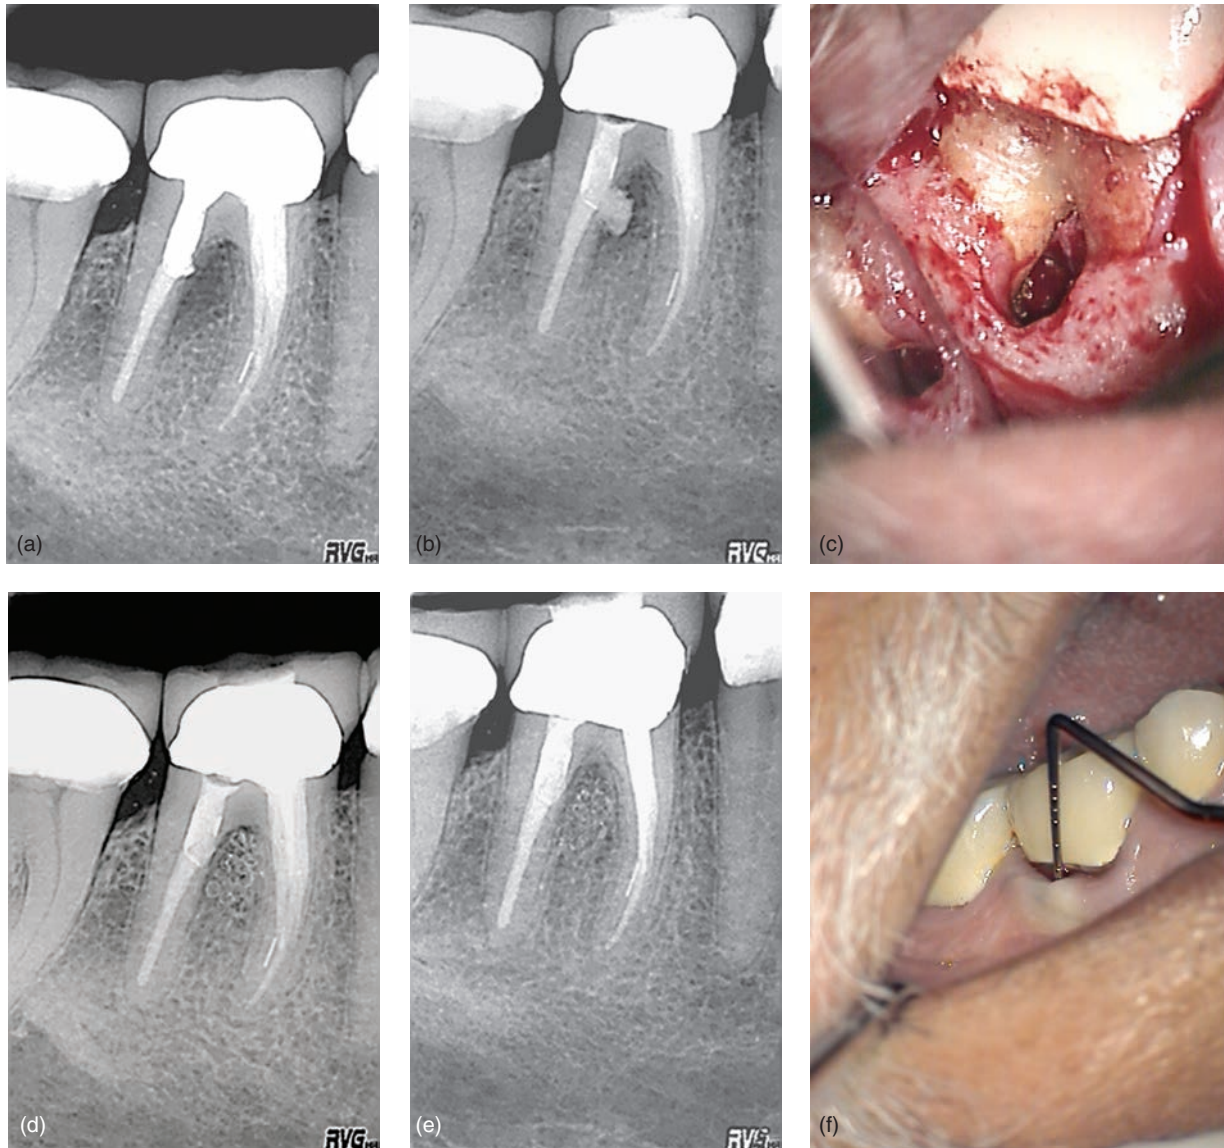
Post perforation on the distal root of a mandibular right first molar causing a furcation defect and deep probing. The perforation was repaired with MTA through the distal canal after removing the post and then a surgical approach to remove excess MTA from the furcation area. (a) Radiograph showing perforation of the distal root into the furcation; (b) MTA was pushed through the perforation site and into the bony defect after the post was removed; (c) surgical approach to remove excess MTA; (d) postoperative radiograph showing synthetic graft placed in the furcation; (e) 14 month postoperative radiograph showing complete osseous healing in the furcation; (f) soft tissue healing and normal periodontal probing 14 months following the surgical perforation repair.
